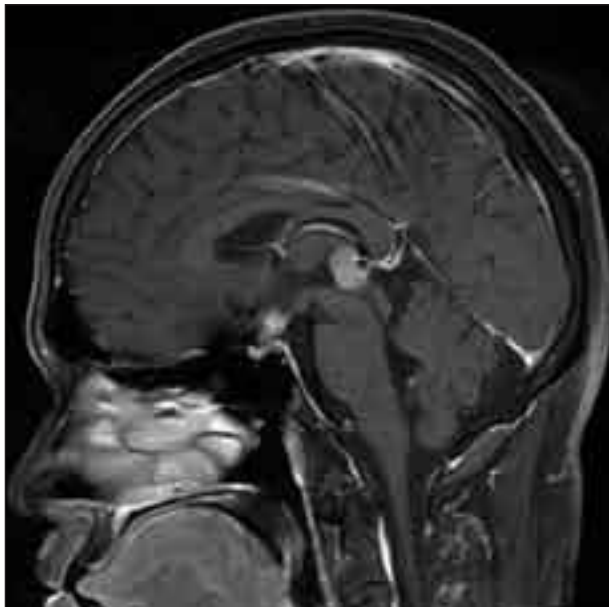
Sagittal MRI scan with increased signal intensity at the pituitary stalk. A transsphenoidal approach to the suprasellar cistern was performed, and biopsy revealed germinoma.
